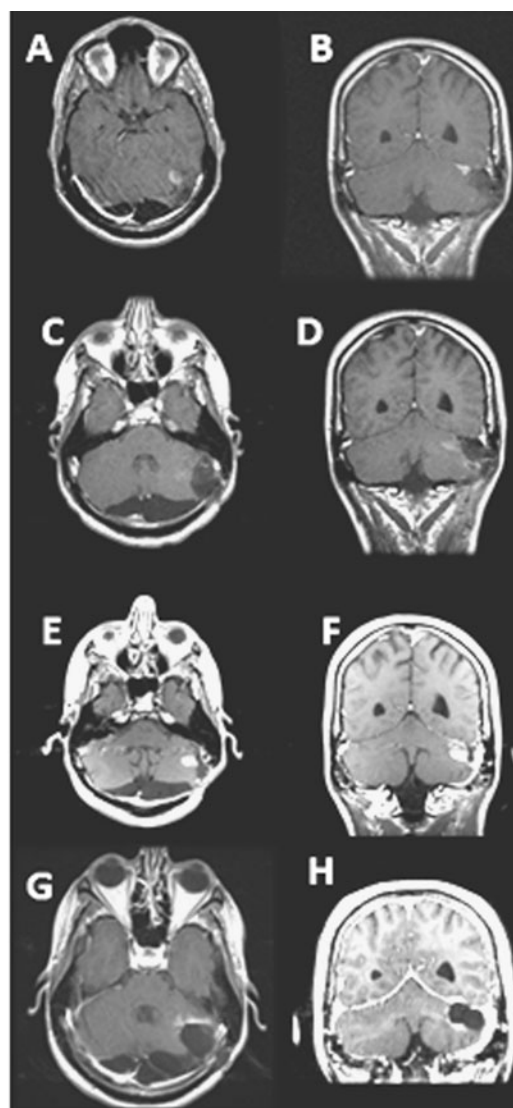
Axial and coronal images of Brain MRI at various stages. a,b: nodular enhancement in left cerebellar region. c, d: status post resection. e,f: persistent nodular enhancement in left cerebellar lobe. g,h: status post resection. a, c, e, g are axial post-gadolinium T1 images and b, d, f, h are coronal post-gadolinium T1 images
